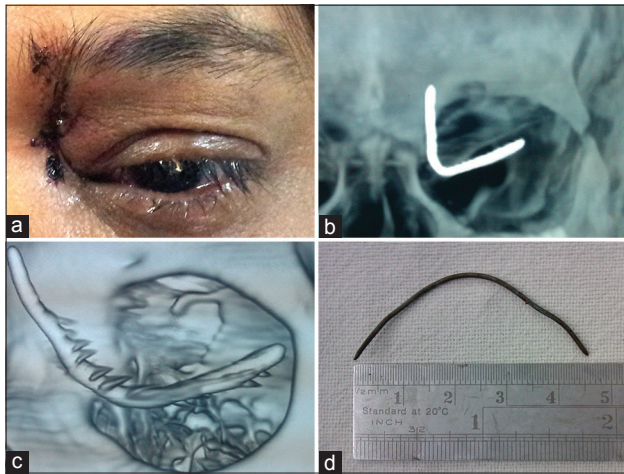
(a) Clinical photograph showing metallic foreign body protruding through left upper eyelid, (b) computed tomography scan of the orbits showing the “L-” shaped metallic foreign body, (c) computed tomography scan three-dimensional reconstruction showing spike-like protrusions along the foreign body (streak artifacts), (d) foreign body measurement after removal
